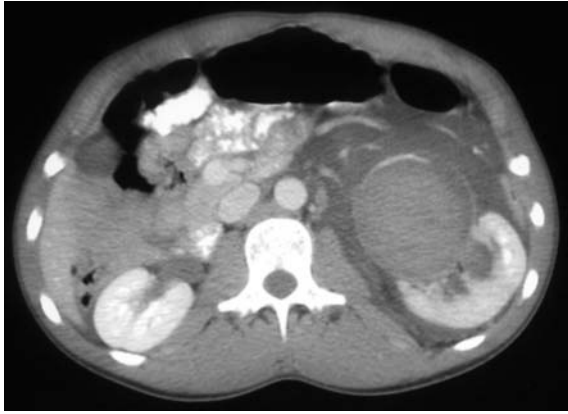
A 12-year-old boy was admitted with renal trauma after receiving a seemingly trivial blow to the abdomen while at school. The CT scan demonstrates extensive extravasation and blood clot within the dilated left renal pelvis. Exploration confirmed rupture of the renal pelvis associated with pre-existing pelviureteric junction obstruction. There was full recovery and preservation of normal differential function following repair of the renal pelvis and pyeloplasty.
